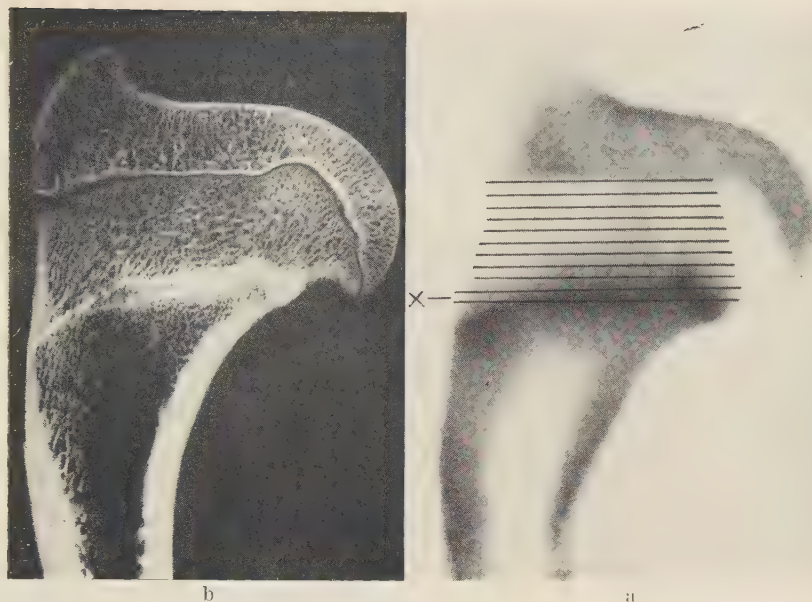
a. Autoradiogram of slab of bone taken from proximal end of right humerus (magnification $1.5\times$). b. X-ray picture of same slab of bone at same magnification.
